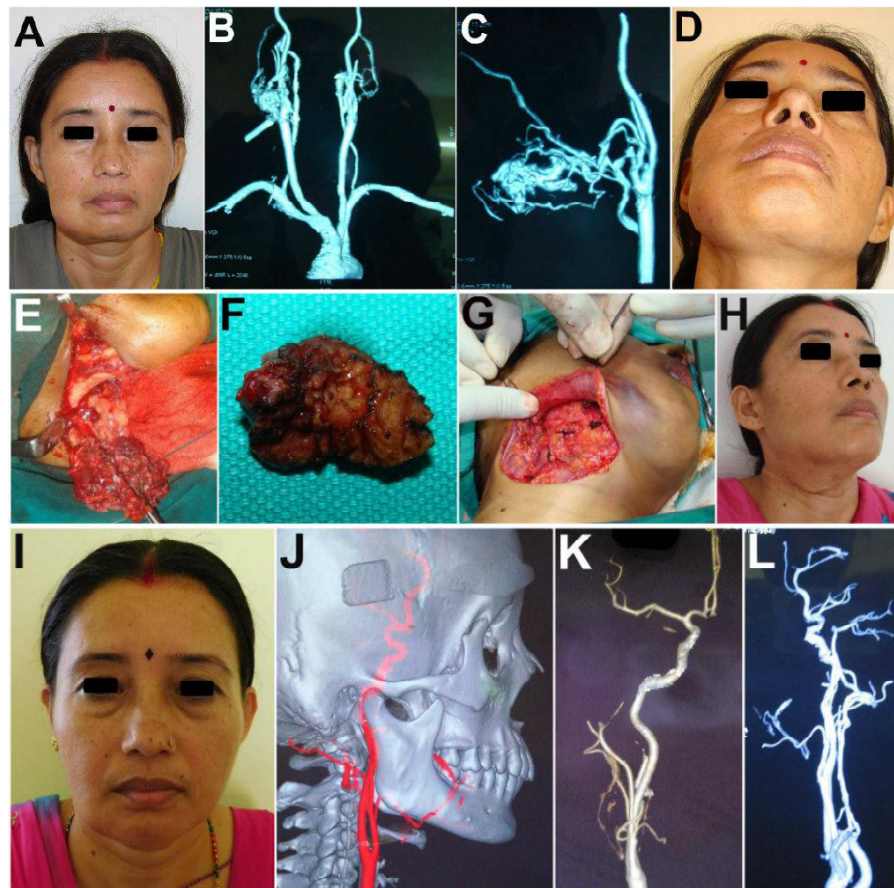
A Middle aged female patient presented with a diffuse swelling in the Right Submandibular region. B, C CT-Angiogram showing a vascular lesion involving Facial and Lingual arteries. D Post Hot water injection. E, F, G Submandibular approach for excision of the lesion and ligation of the feeder vessels. H, I Two years Post-op appearance. J, K, L Two years Post-op CT Angiogram.
